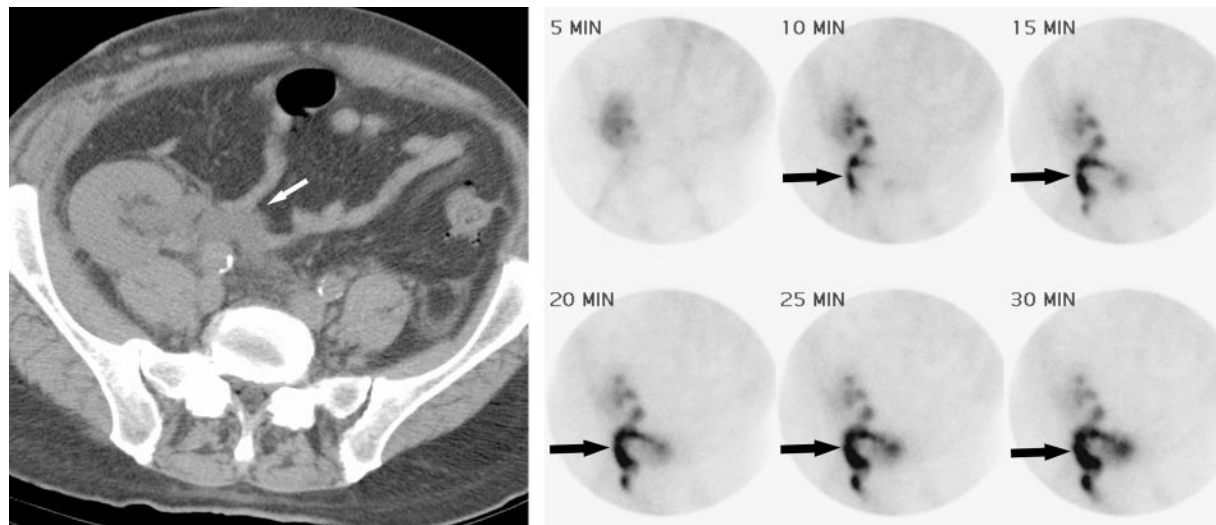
Renal urine leak in a 57-year-old man with oliguria and renal insufficiency. The patient had undergone renal transplantation 1 week earlier. (a) CT scan of the right lower quadrant of the transplanted kidney demonstrates a fluid collection medial to the right ureteropelvic junction (arrow). (b) Sequential dynamic images obtained at renal scintigraphy with technetium-99m dimercaptosuccinic acid help confirm an anastomotic leak at the level of the transplant ureteropelvic junction, with progressive accumulation of radiotracer outside the collecting system over time (arrows).
